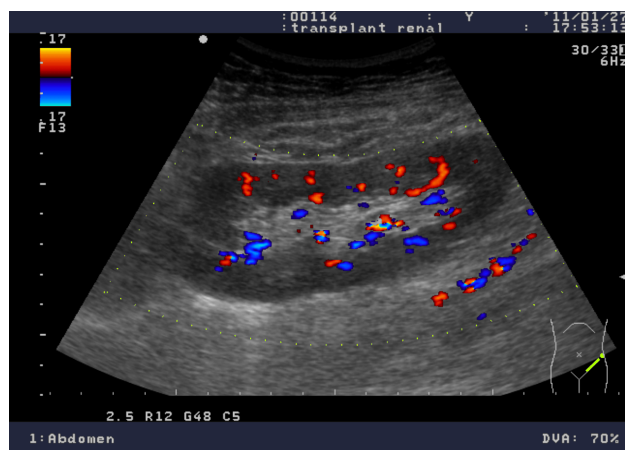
Ultrasound exam: functional *de novo* kidney allograft.
